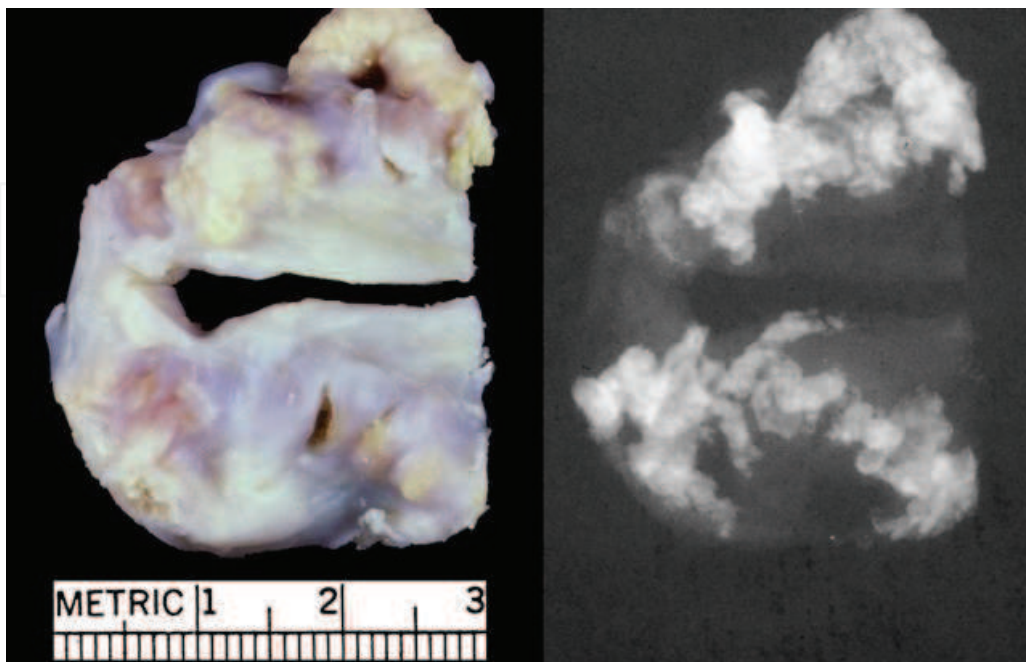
Unicommissural AS (1983, 2-283-534, Eaton 42M), with x-ray
